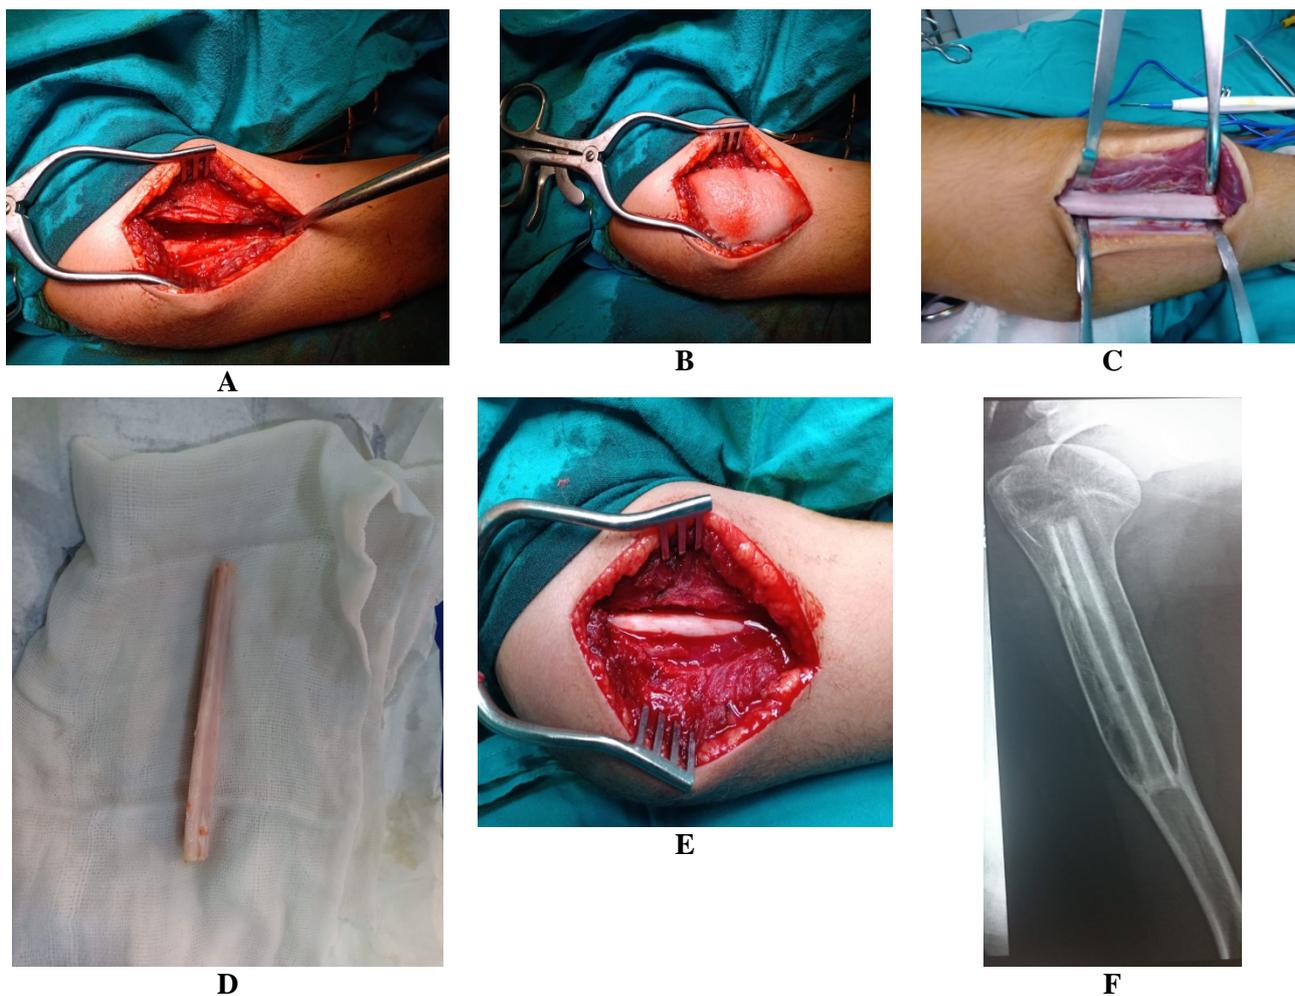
A,Cortical window with thorough curettage. B, Wash with saline and hydrogen peroxide. C, Subperiosteal harvesting of fibular graft. D, non-vascularized fibular graft. E, impaction of the fibular graft. F, follow up X-ray showing healed lesion.
